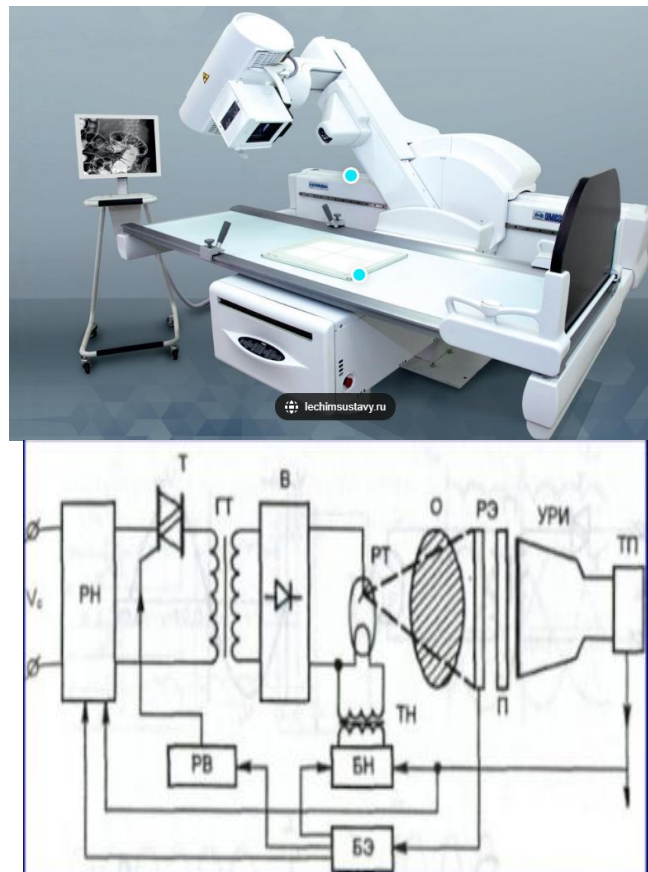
Modern X-ray machine
